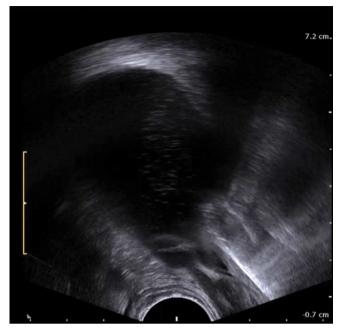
Ultrasound imaging enables continuous monitoring of the laser fiber tip location during energy emission. In this case, the moment of the penetration of the laser fiber tip into the ectopic ureter lumen was captured. It is accompanied by the appearance of a hyperechoic gas trail, forming at the tip of the fiber on the background of transsonic urine. The examination was performed with a transrectal end-fire probe with the frequency of 12 MHz (ProFocus Ultraview, BK Medical, Denmark)
